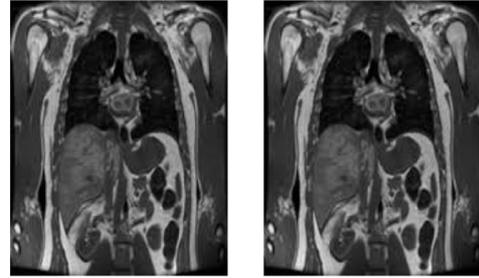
MRI test image b) MRI image after watermarking
